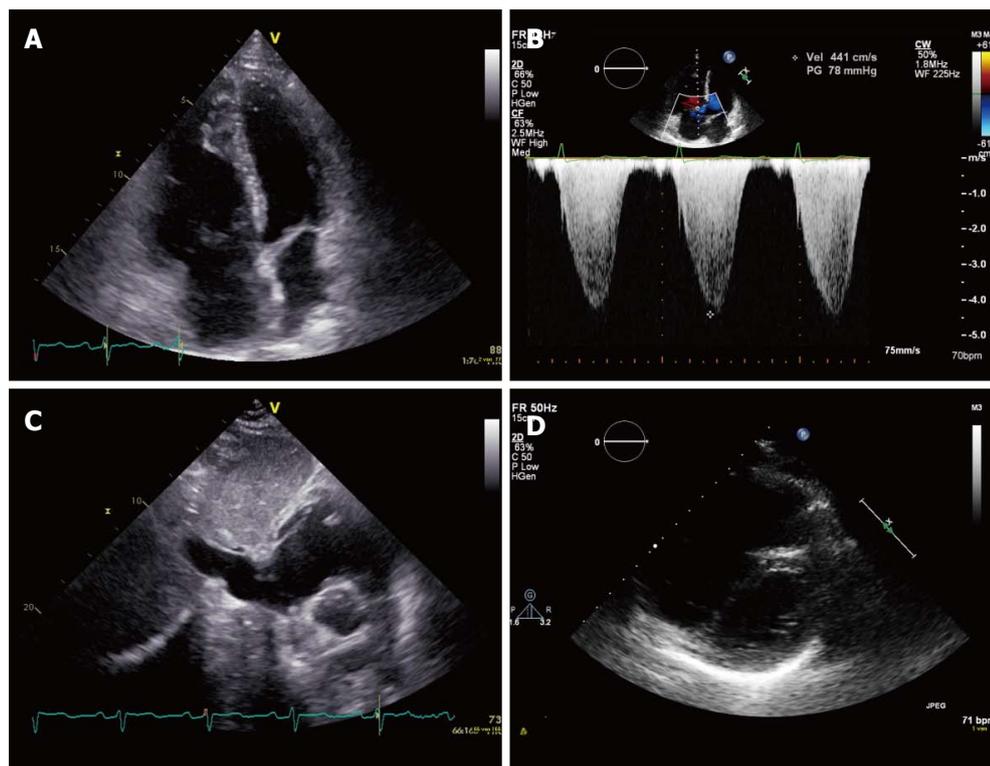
Characteristic echocardiogram of a patient with pulmonary hypertension. A: Apical 4-chamber view showing dilatation of the right ventricle; B: Apical 4-chamber view with Doppler signal (continuous wave) showing an increased right ventricular- right atrial pressure gradient (4.4 m/s); C: Subcostal view showing dilatation of the inferior caval vein corresponding with an increased pressure in the right atrium; D: Parasternal short axis view showing flattening of the interventricular septum (D-sign) and dilatation of the right ventricle.
